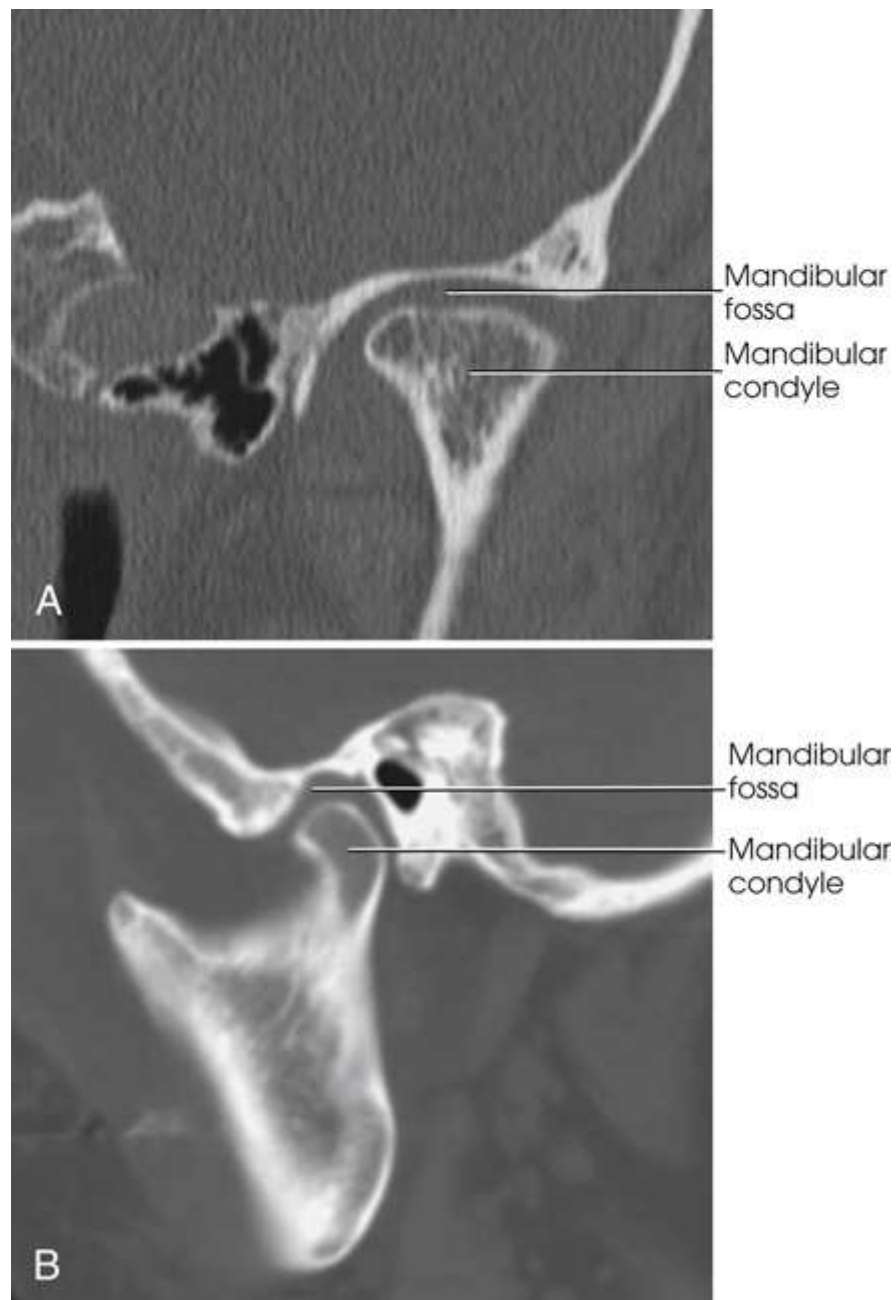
CT scan of mandibular condyle situated in mandibular fossa. (A) Coronal. (B) Sagittal. Courtesy Karl Mockler, RT[R].
